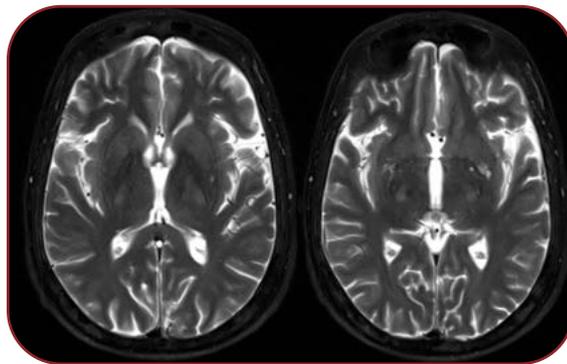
MRI of the brain showing a subtle T2 hyperintensity in the internal capsule
